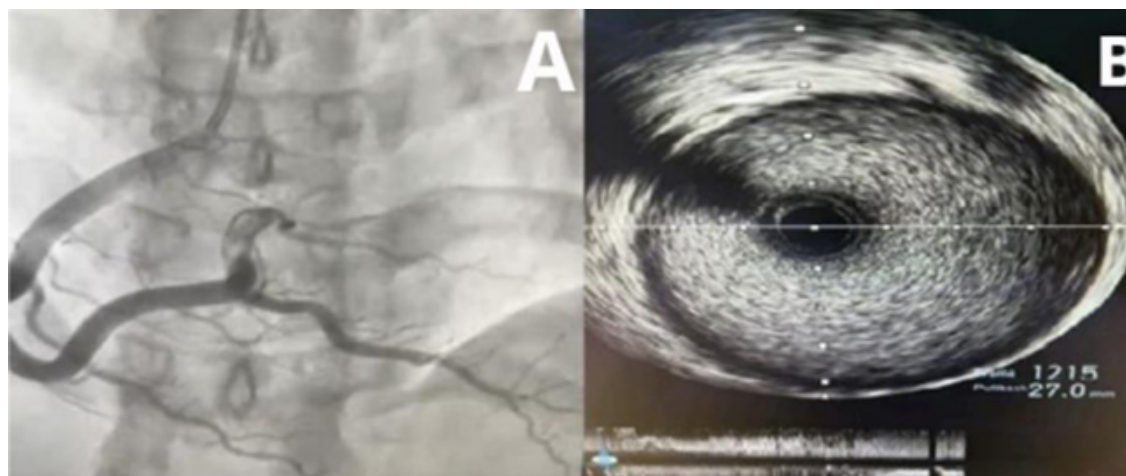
A) Coronary angiography in the right anterior oblique projection demonstrating a negative image suggestive of thrombus in the right posterior ventricular artery. B) Intravascular ultrasound performed at the site of the thrombotic image after 5 days of antithrombotic therapy, demonstrating intact endothelium, absence of atherosclerotic plaque, and adequate luminal area. Source: Author's personal archive.
